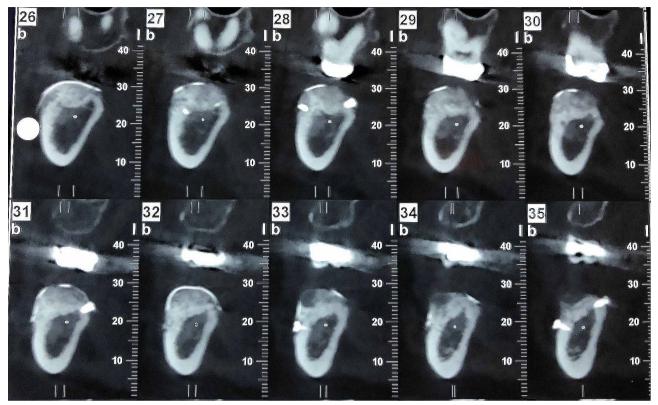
CBCT 5 months after surgery.
